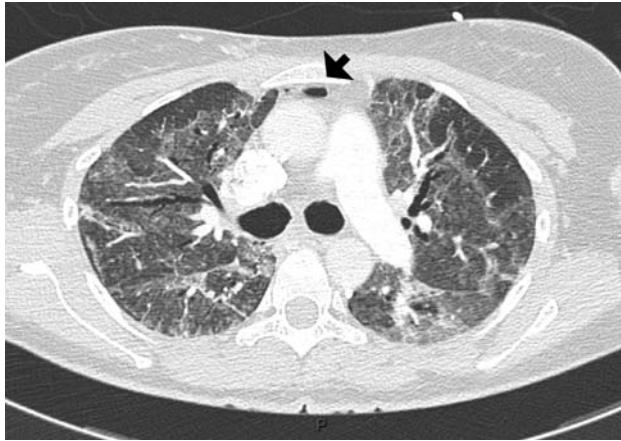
Multidetector CT angiography performed on 21 August demonstrating parenchymal lesions suggestive of fibrosis development, with worsened bilateral ground-glass opacities, mild-to-moderate dilatation of the bronchi and air in both anterior mediastinum and cervical soft tissue (arrow)
